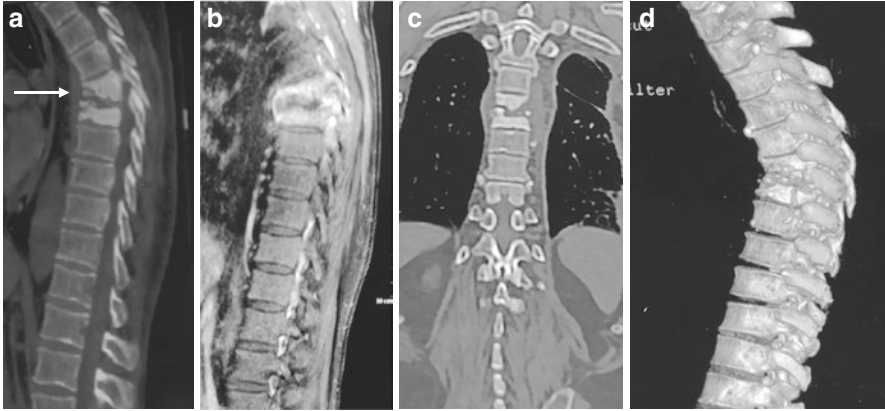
CT spine sagittal (a), coronal CT (c) and virtual reconstructed 3D image (d) reveals loss of D4/5 intervertebral disc space with simultaneous destruction of the adjacent contiguous vertebrae (D4 and D5) causing a focal kyphotic deformity (arrow). T1 weighted post-contrast sagittal image (b) showing the paradiscal involvement of the D4 and D5 vertebrae with intervening disc involvement
